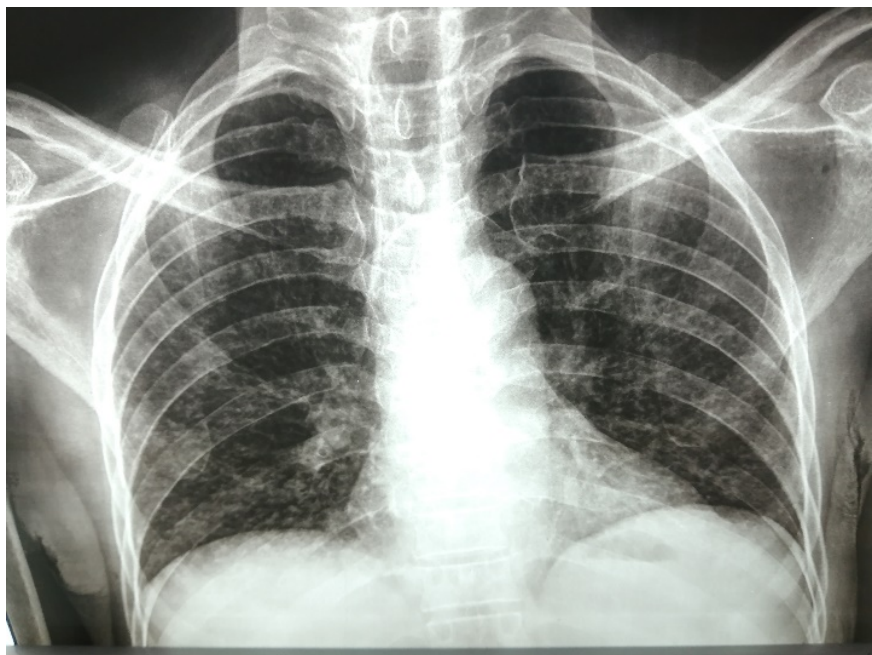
Chest X-ray: absence of visible organized parenchymal focus.
